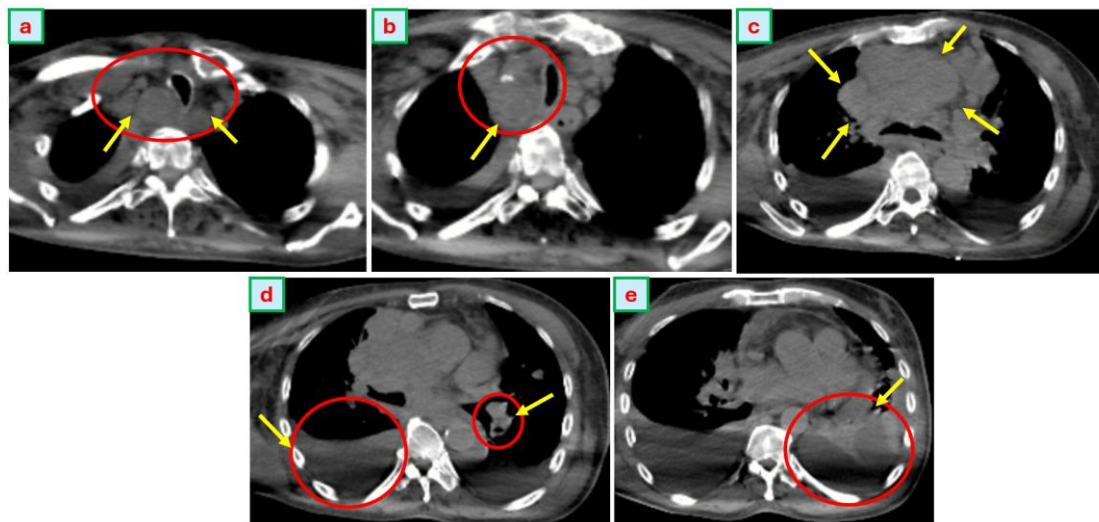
Thoracic CT scan with Contrast at Second Hospitalization
